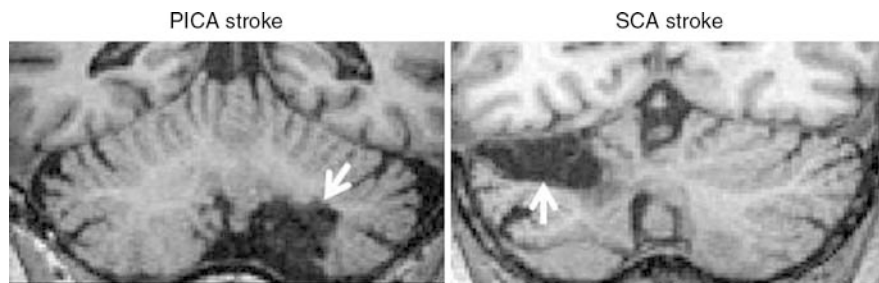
Coronal views of T1-weighted MR images of a chronic posterior inferior cerebellar artery (PICA) infarct (*left*) and a chronic superior cerebellar artery (SCA) infarct (*right*)
